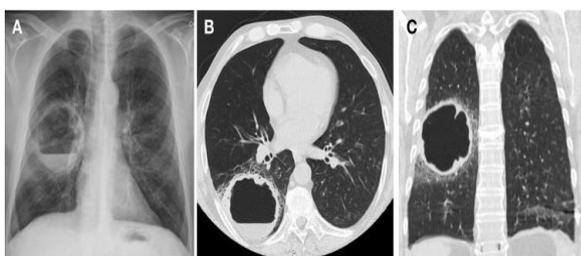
A) Chest-Xray examination; B) and C) CT-scan showing the cavities in the lung abscess.<sup>14</sup>
